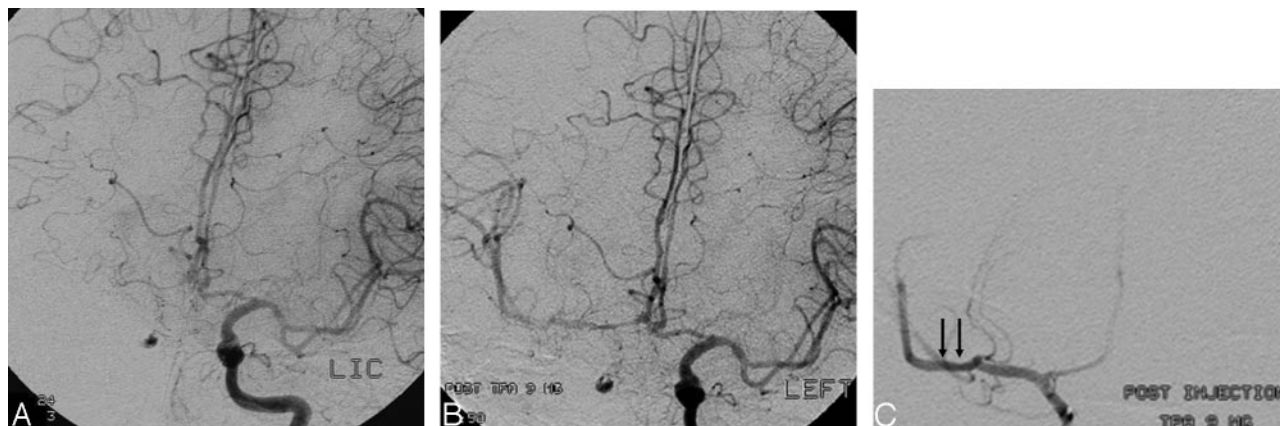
A, Diagnostic angiogram of the left internal carotid artery (ICA) reveals good flow across the anterior communicating artery (AcomA) but poor filling of the right MCA territory because of a thrombus demonstrated on an earlier CT angiogram.
